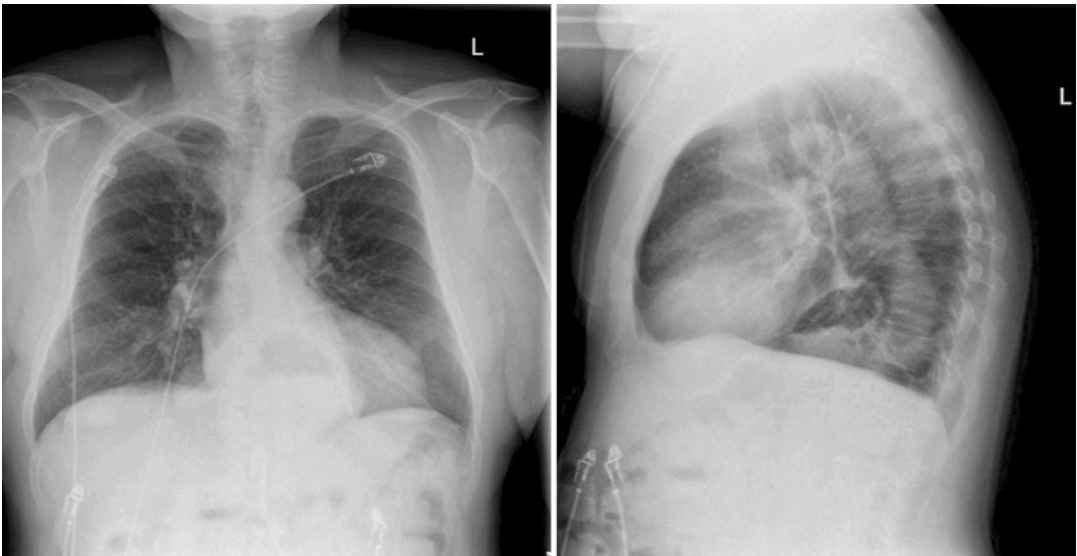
Plain chest radiograph with hiatal hernia. Open access from [19]
